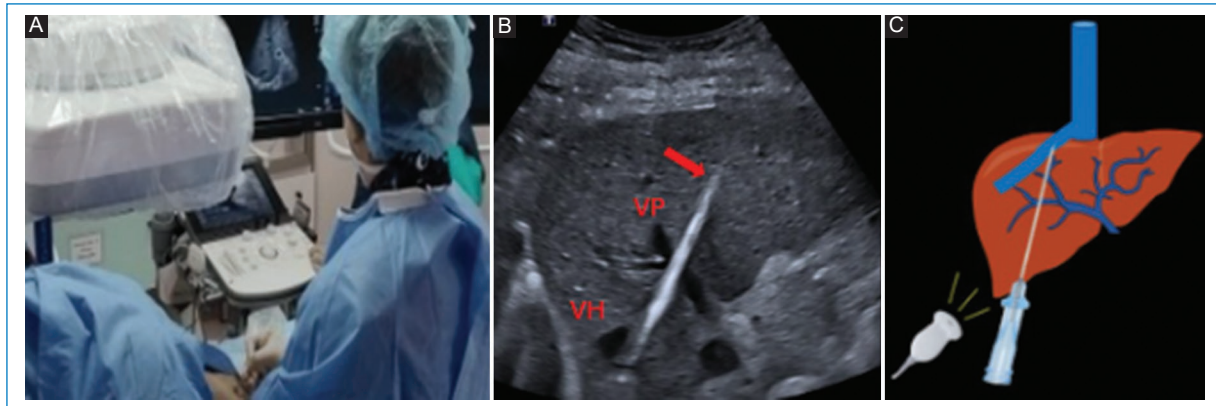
A and B: ultrasound-guided transhepatic needle puncture (arrow) of the selected portal vein (VP) and hepatic vein (VH). C: graphic representation.
